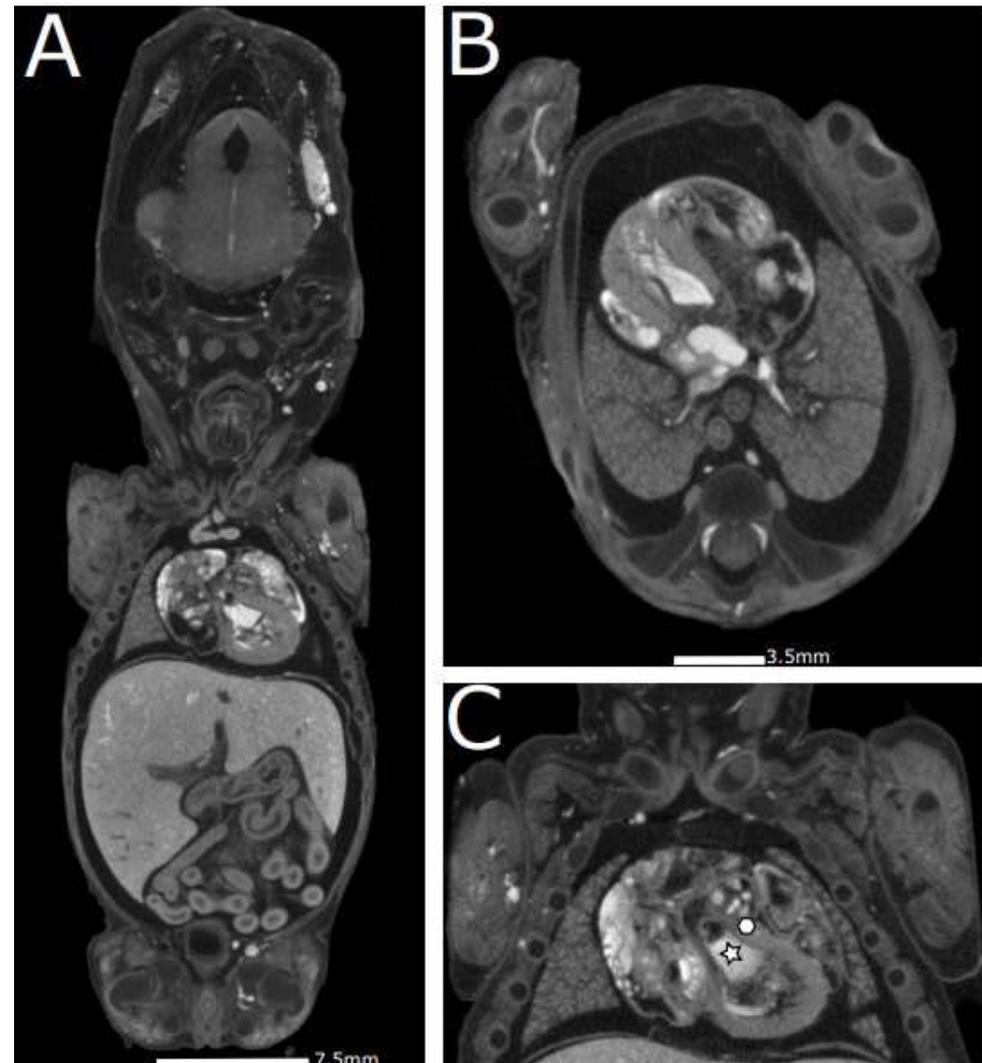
Micro CT of a phenotypically normal fetus (case 12) at 11 gestational weeks (A). Axial (B) and Coronal (C) analysis of the heart reveals the aorta (star) and pulmonary trunk (hexagon).
